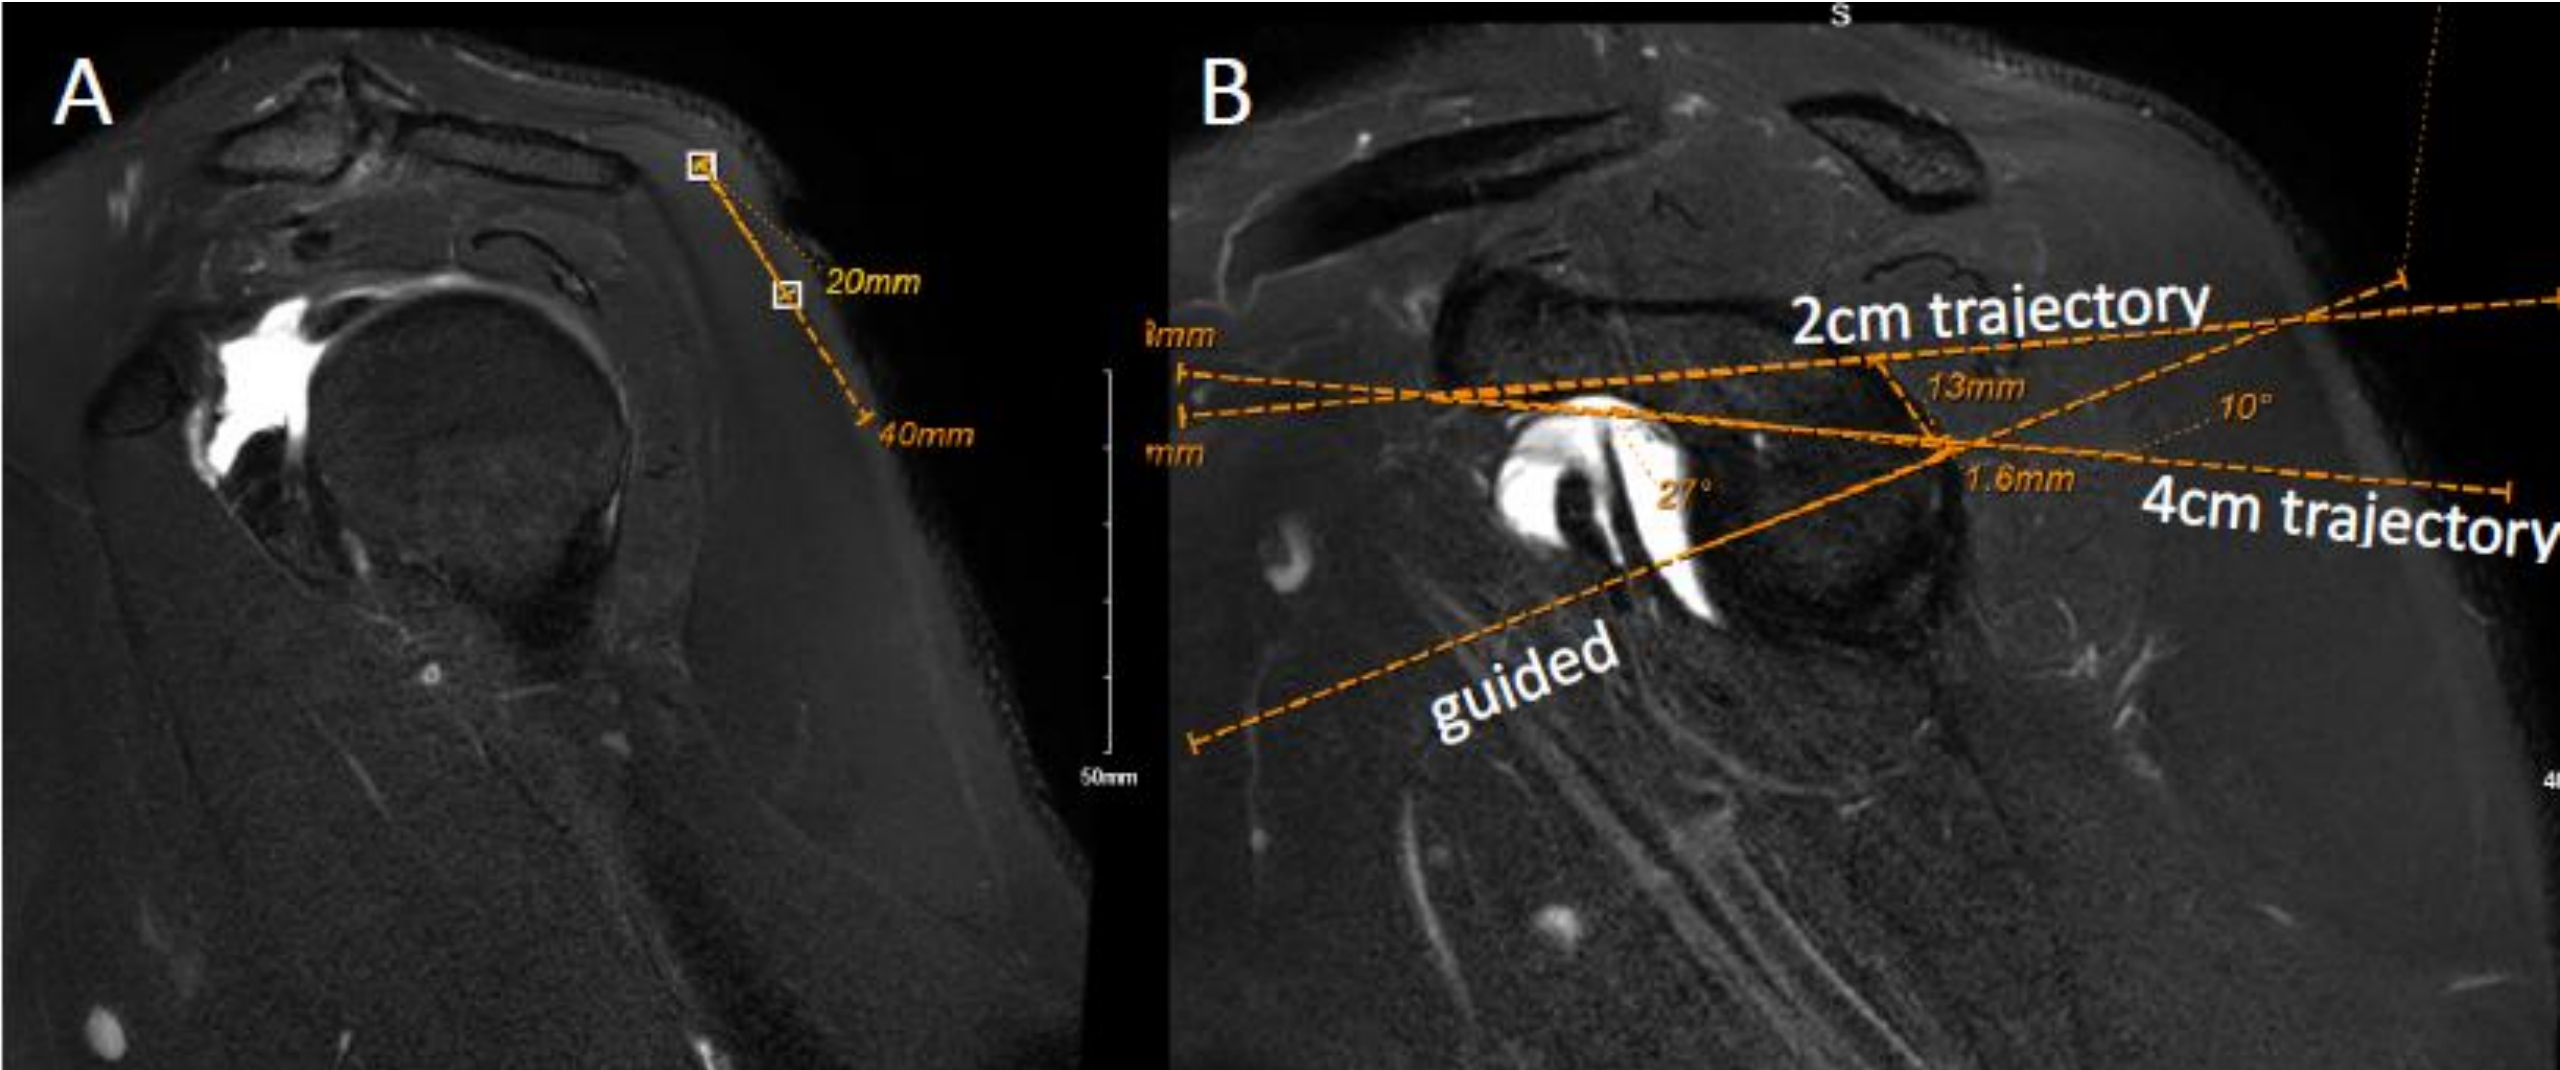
(A) Using set distances of 2 and 4 cm from the acromion on MRI, (B) positions and angles of unguided portals with respect to the horizontal equator were measured.
